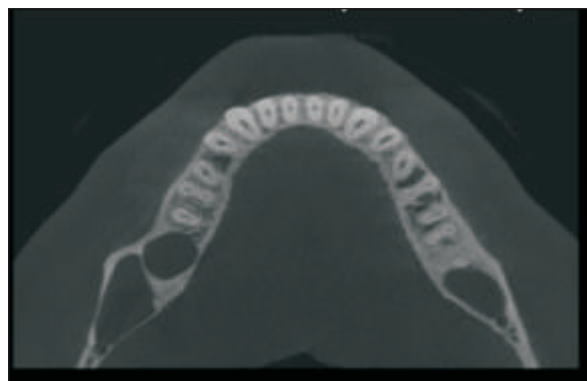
CBCT Showing bony expansion in axial view in case of periapical pathology
